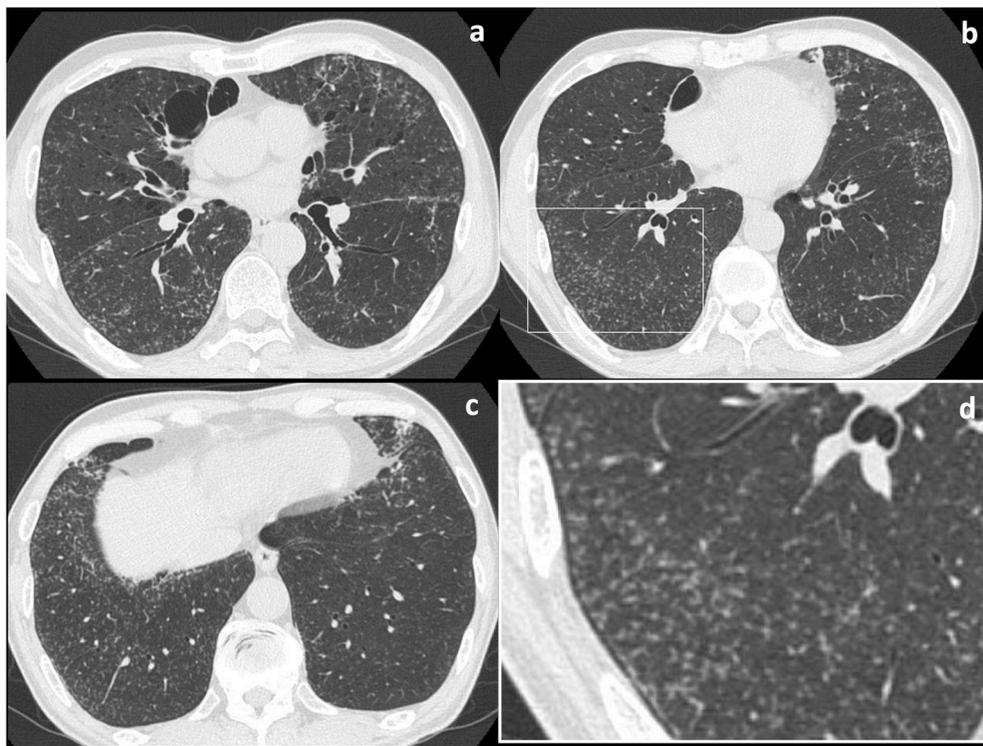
a-c. Serial chest computed tomography images showing diffusely distributed centrilobular nodules and branching structures away from the pleura and interlobular septa. d. Enlarged area in b.
